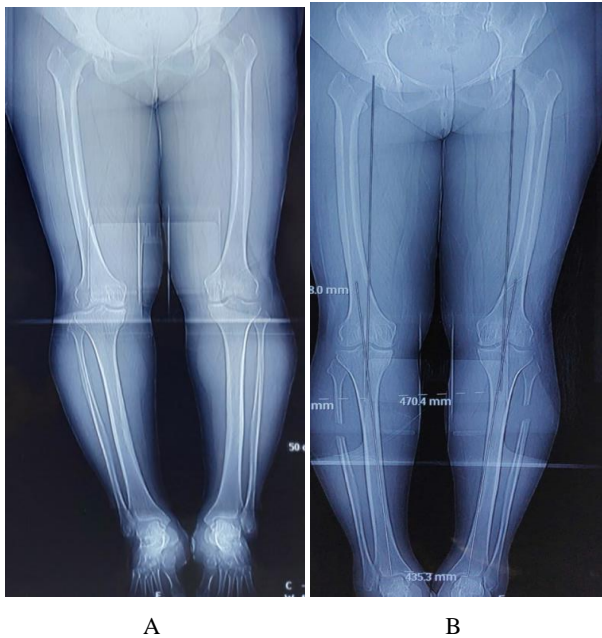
Improvement in the axial alignment of the lower extremity in a 54 year old woman with a 6 year history of bilateral knee joint pain A. Weight bearing radiograph of whole lower limb showing bilateral genu varus before proximal fibular osteotomy B. Correction of lower limb alignment after proximal fibular osteotomy
